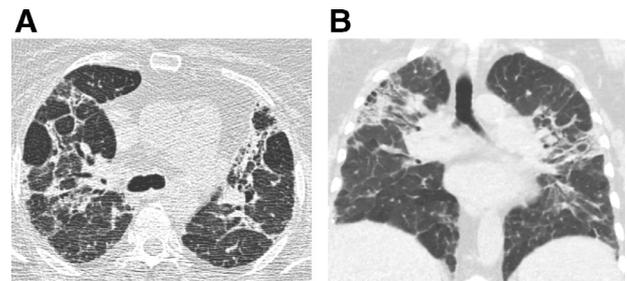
Axial (A) and coronal (B) images from HRCT demonstrate axially diffuse and mid/upper lung predominant reticulation, traction bronchiectasis, architectural distortion, and extensive mosaic attenuation, most consistent with a non-IPF diagnosis (formerly inconsistent with UIP). Overall, findings are highly suggestive of HP, which was the eventual multidisciplinary diagnosis.
